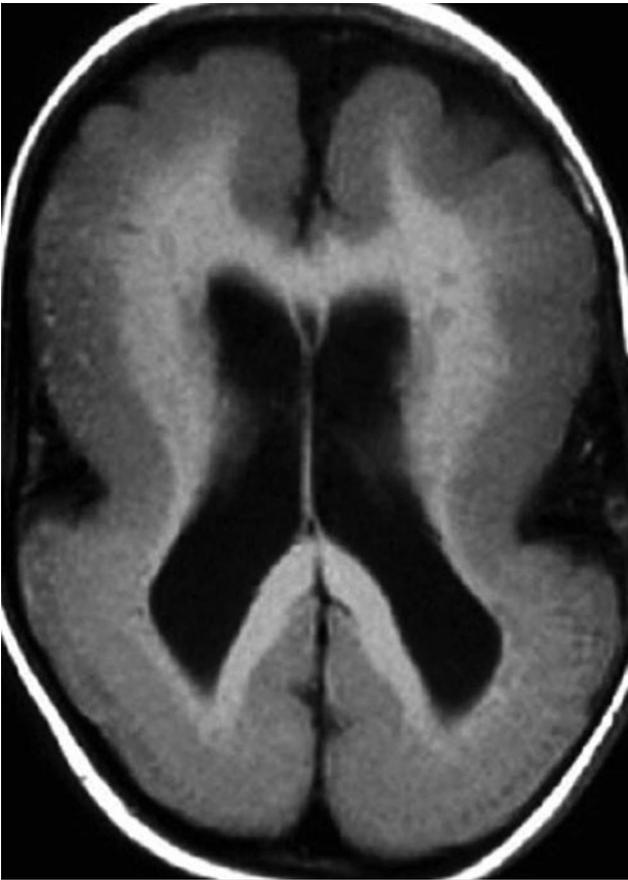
Axial T1-weighted magnetic resonance image of classic lissencephaly (type 1) shows a smooth cortical surface with minimal gyri and sulci at the frontal lobes. The shallow sylvian fissures give the brain an "hourglass" configuration.
